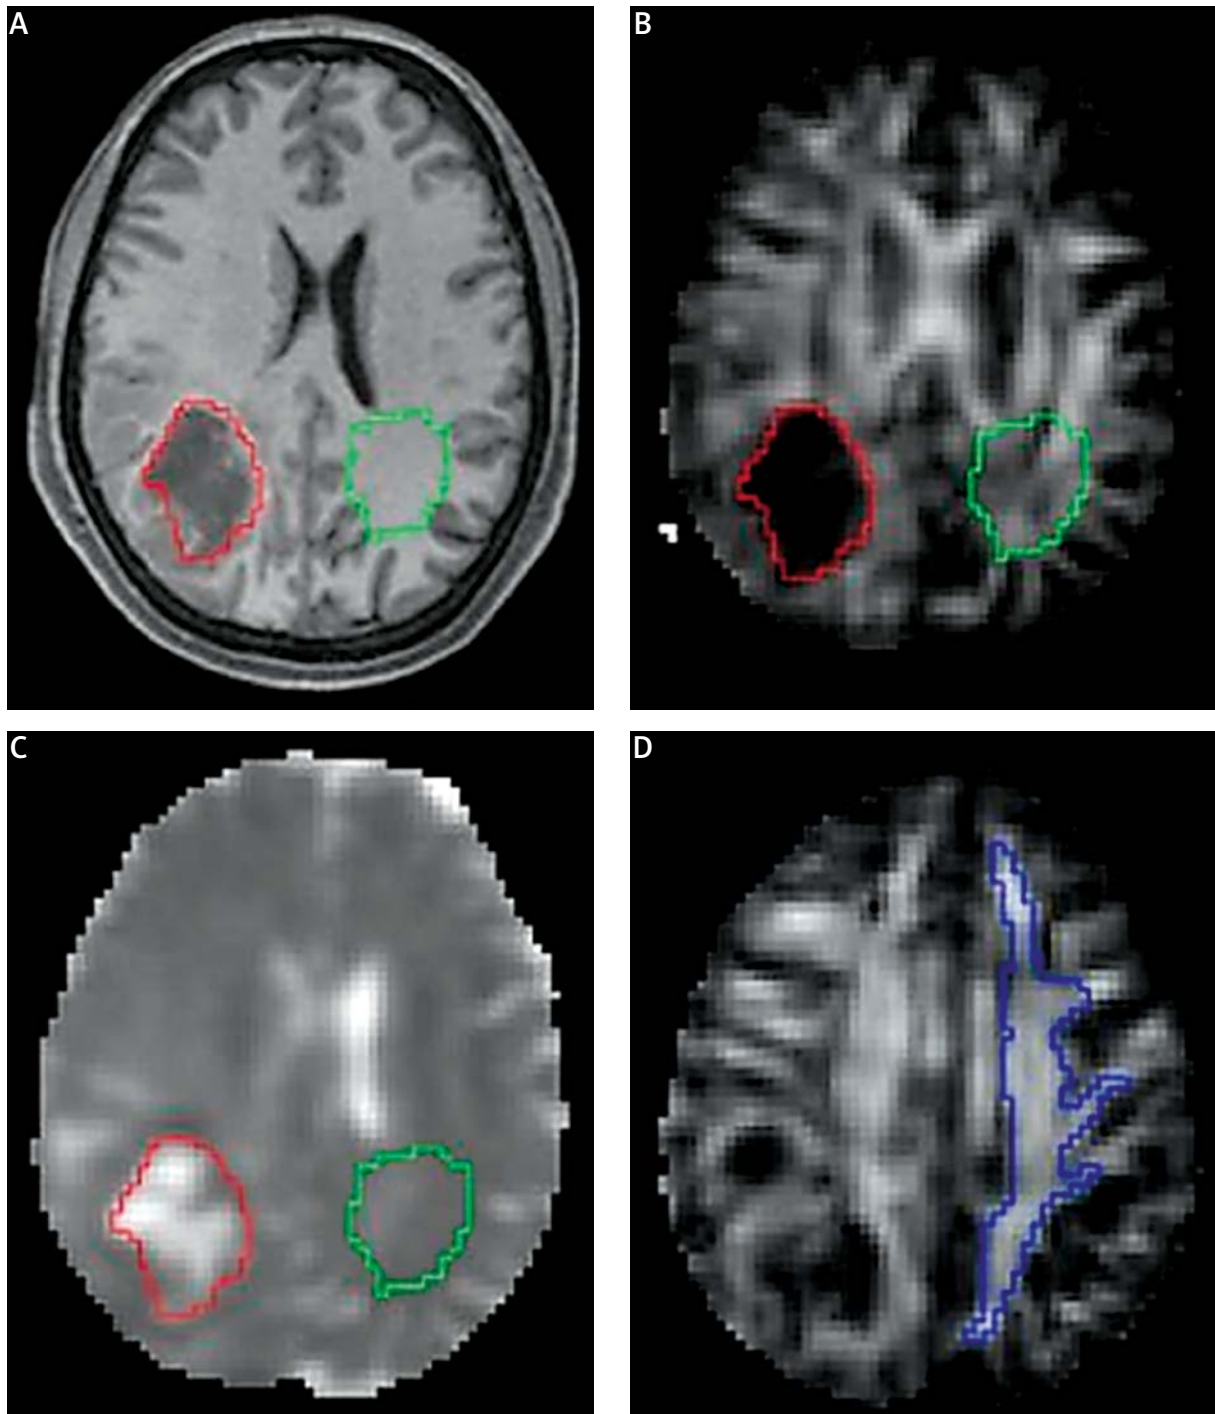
A) Axial section of the 3D T1-weighted data set, B) FA map, C) ADC map, D) FA map 2 mm cranial of the left ventricle. The tumor is surrounded by a red line. A green line defines the ROI_c in the contralateral hemisphere mirroring the tumor; the blue line defines the Hemisphere_c in the white matter of the contralateral hemisphere (D).
